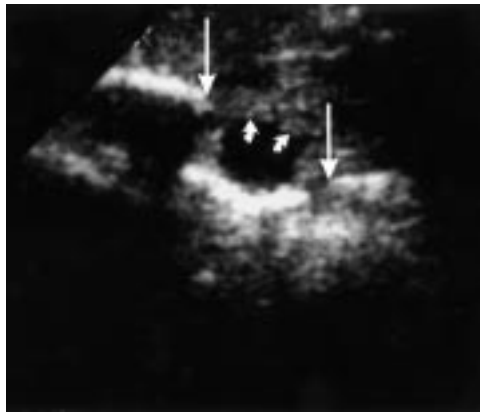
Preoperative ultrasound image (case 6) showing a dilated lacrimal sac (small arrows) and the vertical limits of the lacrimal sac fossa (large arrows).
